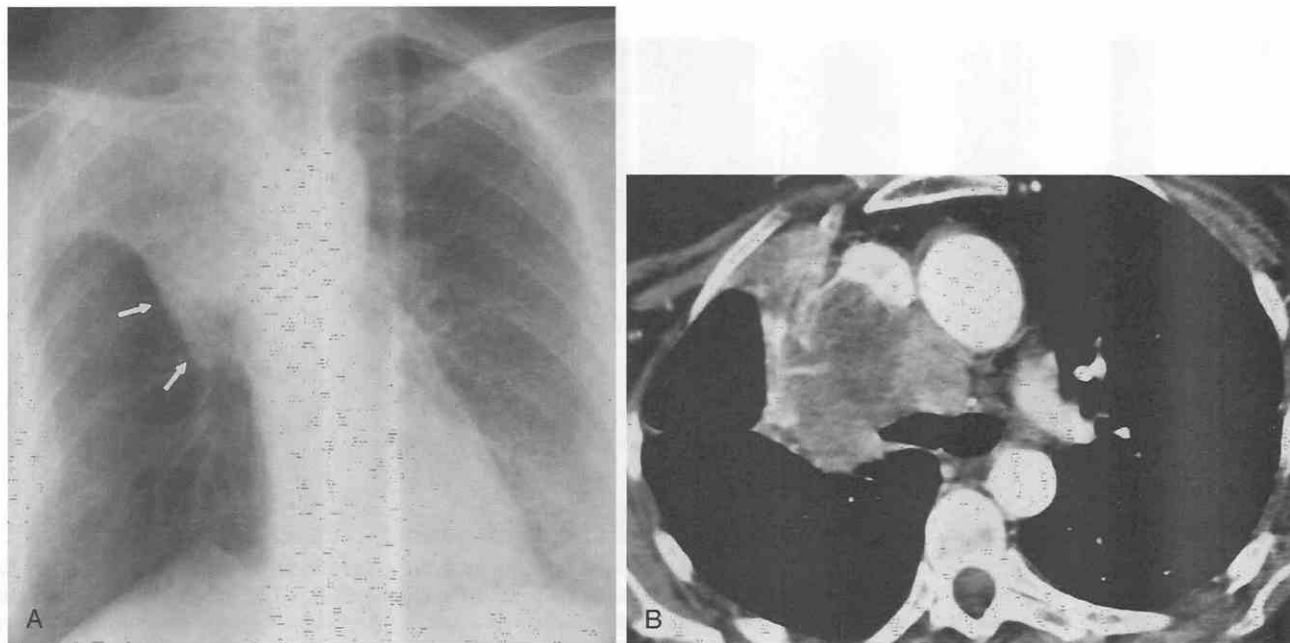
Small-cell lung cancer seen as intrathoracic adenopathy and atelectasis. *A*, Posteroanterior chest radiograph shows complete atelectasis of the right upper lobe with mild convexity of the distal aspect of the minor fissure (arrows) caused by an underlying right hilar mass. *B*, CT scan confirms marked hilar and mediastinal adenopathy and reveals occlusion of the right upper lobe bronchus.
